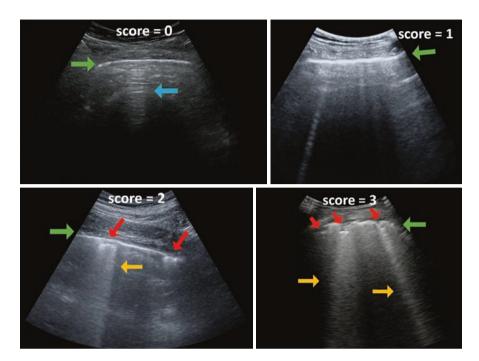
COVID-19 severity scores. LUS frames exemplifying the severity score of [73] from healthy (score = 0, top left) to severe (score = 3, bottom right). One can observe the pleural line (green), A-lines (blue), subpleural consolidations (red) and vertical artifacts (e.g., B-lines and "white lung") (yellow). While the pleural line and consolidations are anatomical features, the A-lines and vertical artifacts are sonographic echoes. (Figure taken from [79])
